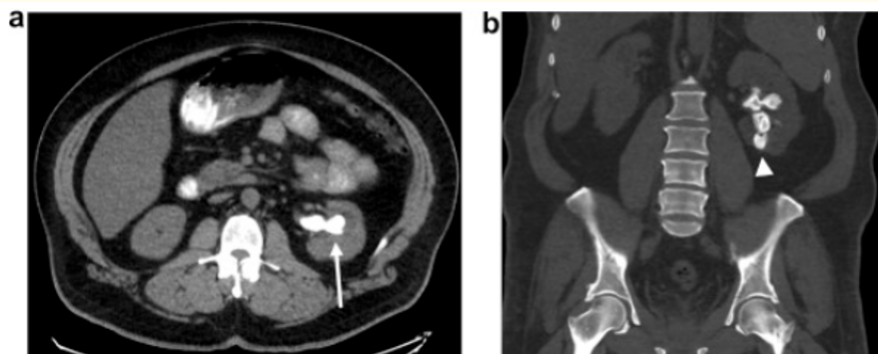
A. Axial and B. Coronal view of non-contrast CT showing a large staghorn calculus (arrow) occupying the majority of the left renal collecting system [11].
